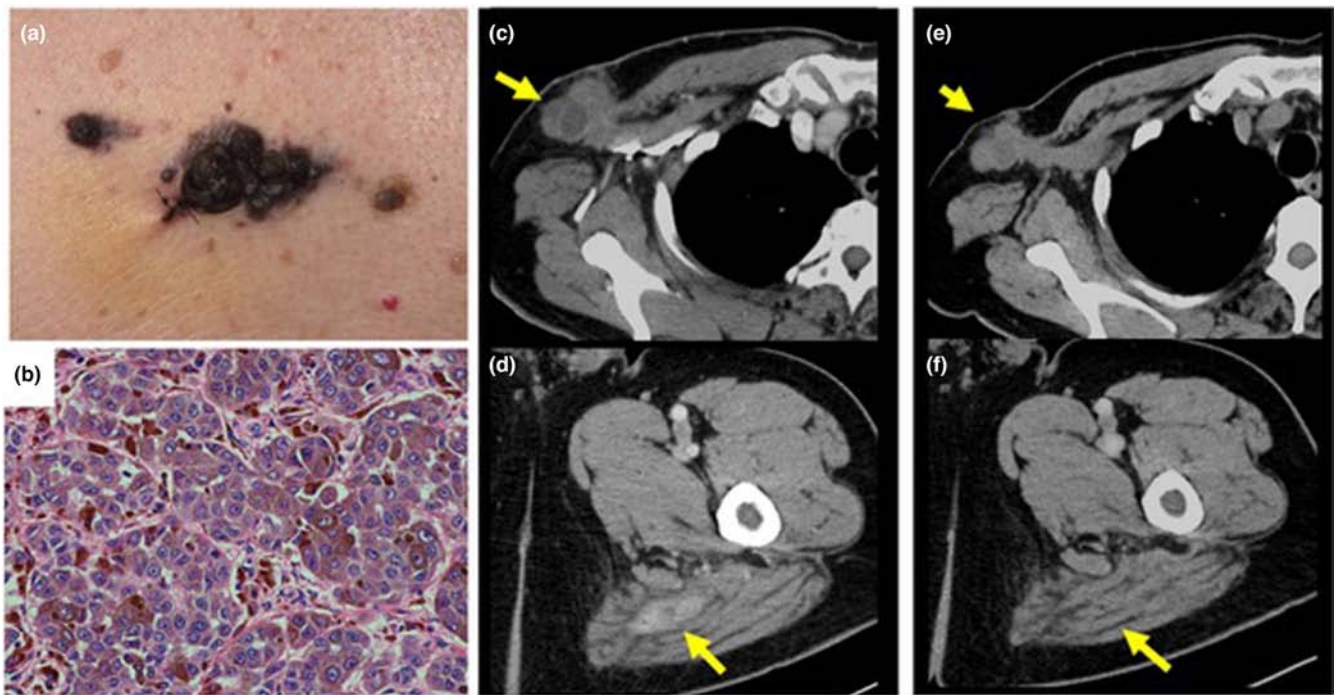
(a) Clinical features at initial examination. A dark brown nodule of approximately 20 mm in size, with an undefined border, and ulceration was visible on the chest. (b) Pathology. Atypical melanin-containing large cells infiltrating the deep dermis with lymphatic invasion. The tumor thickness was 4.6 mm and all lymph nodes from both axillae had metastatic cells. The magnification of figure is 200x. (c, d) computed tomography images obtained immediately before administration of the BRAF/MEK inhibitors. Enlarged metastases in the right axilla, which was adherent to the axillary artery, and in the femoral muscle were detected. (e, f) computed tomography images obtained 2 months after BRAF/MEK inhibitors administration. The axillary lymph nodes and femoral muscle metastases were smaller.
